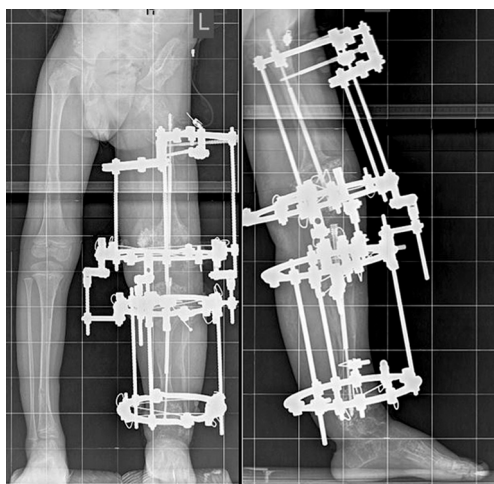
Radiographs on the 10<sup>th</sup> day of lengthening
